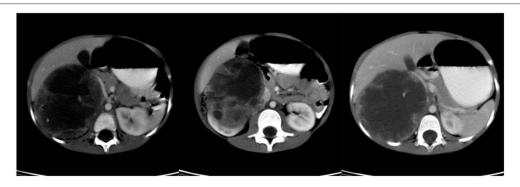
Preoperative CT scan of patient E.
